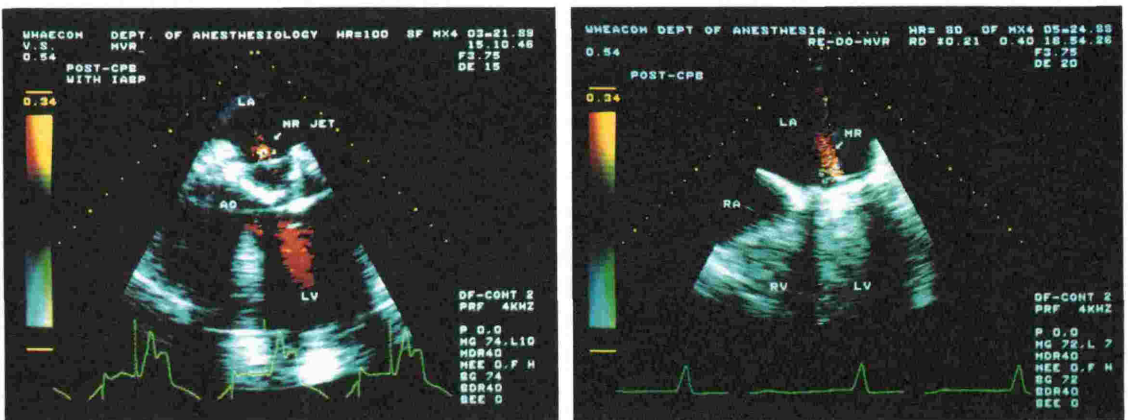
Left: Transvalvular MR jet in Hancock bioprosthesis valve. Right: Medtronic mechanical prosthetic valve shows transvalvular leakage and LV cannot be viewed due to ultrasound interference by metal leaflets.
